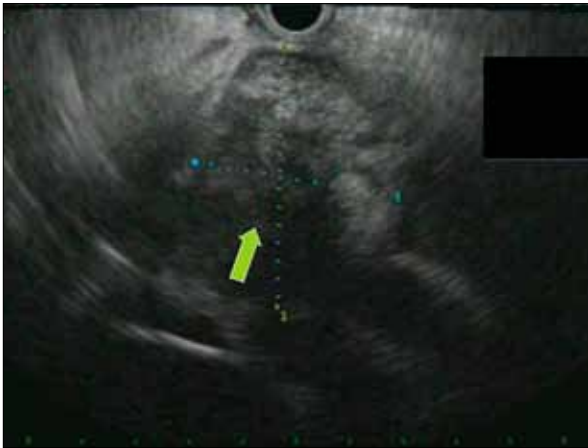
An endoscopic ultrasound of a hypoechoic mass measuring approximately 47 mm × 38 mm (arrow) in the head and proximal body of the pancreas.
